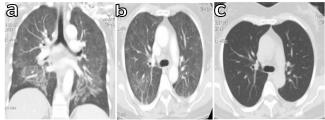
Thorax CT images prior to, and after treatment: an increase in ground glass appearance and interstitial reticulonodular densities can be seen with protected regions of sub-pleural and costophrenic sinuses (a and b). Lung parenchyma appears completely normal 1 month after corticosteroid therapy (c)
